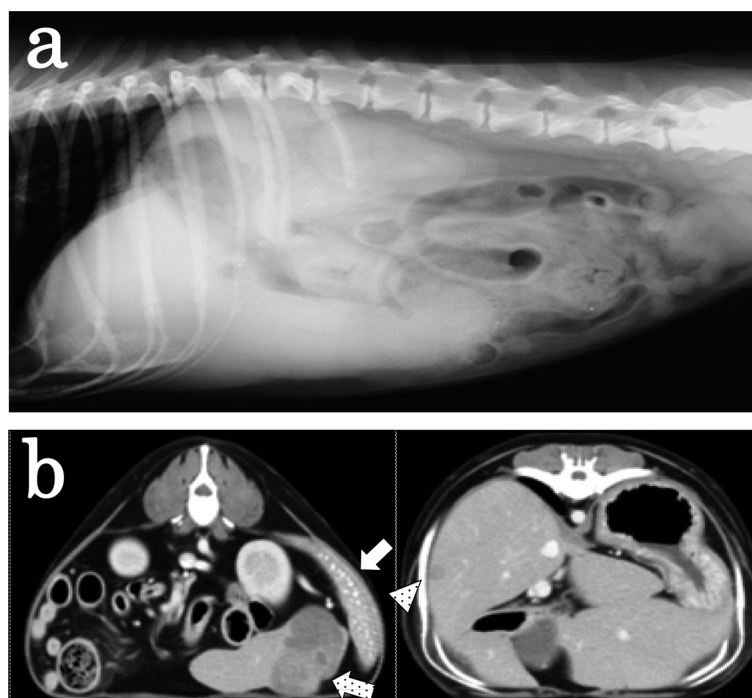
Imaging findings of (a) abdominal radiography and (b) contrast-enhanced computed tomography (CT) performed on day 784. (a) Significant hepatomegaly is observed. (b) A mass on the left lateral lobe (a shaded arrow) and diffuse nodes (an arrowhead) in the liver are detected. Calcification of the spleen is also observed (a white arrow).
